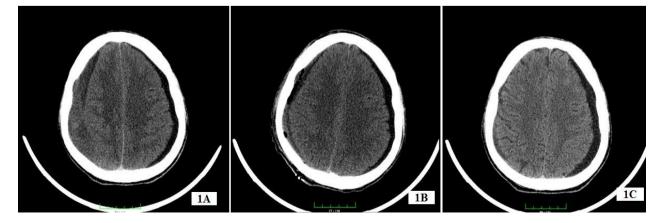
CT images of a patient with chronic subdural hematoma unilaterally; (1A) on admission to hospital; (1B) early postoperative image.
